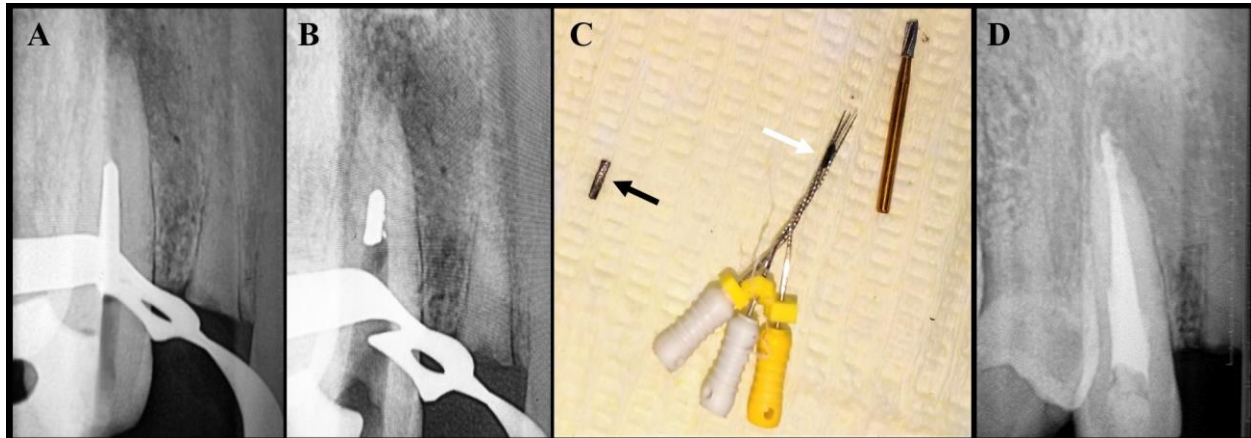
A: Preoperative periapical radiograph showing the separated instrument in the coronal and middle parts of the root canal. B: Intraoperative periapical radiograph showing the apical segment of the secondary-fractured instrument after ultrasonic retrieval of the coronal segment. C: Clinical photograph showing the separated instrument coronal segment retrieved by ultrasonic technique (black arrow), and the apical segment retrieved by the braiding technique (white arrow). D: Postoperative periapical radiograph showing the root canal obturation.
